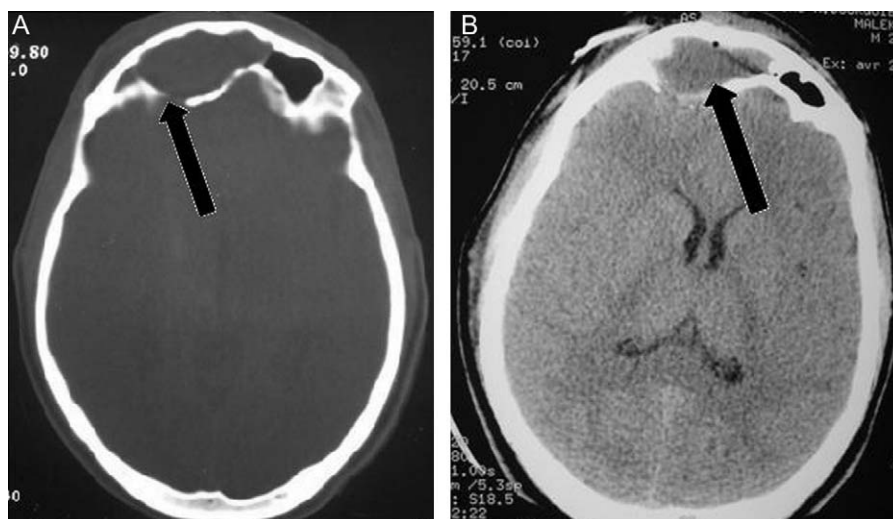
Cranial CT-scan in axial section with iodine contrast injection realized at patient's admission. A. Bone window: obliteration of the frontal sinus with lysis of the right posterior wall (arrow). B. Parenchymal window: obliteration of the right frontal sinus via parenchymatous process (arrow).
